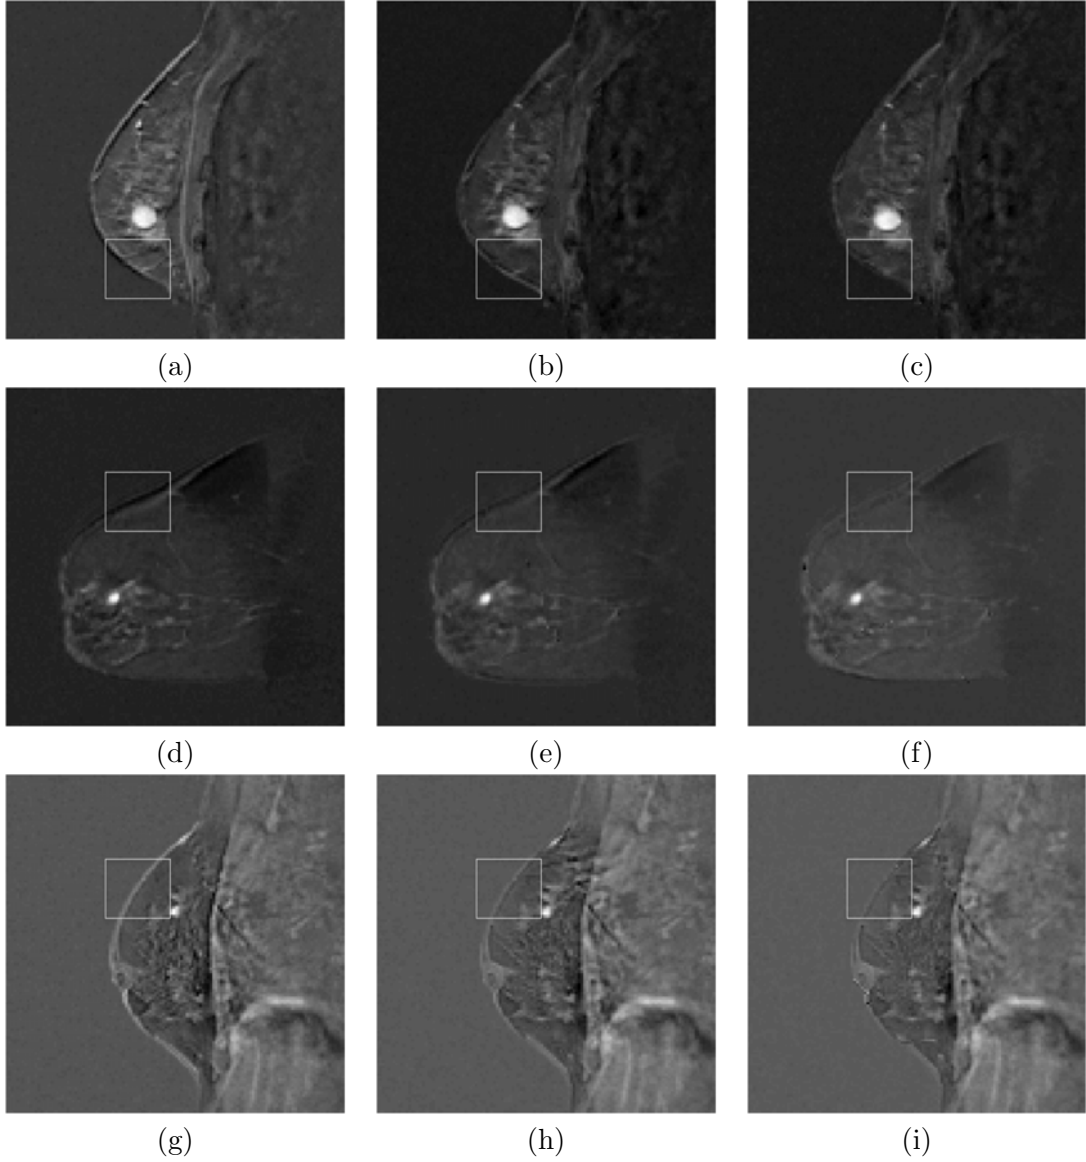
Comparison of unregistered (a, d, g), signal intensity based registration (b, e, h), and SERg (c, f, i) and difference images for 3 different breast DCE-MRI datasets. Inset in bottom-right corner of each image highlights misalignment demonstrated by high signal intensity at breast edge.
